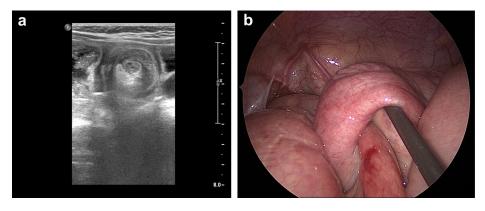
a) Transverse ultrasound image demonstrating small bowel intussusception with classic doughnut or target sign, b) laparoscopic reduction of ileoileal intussusception (involved segment of 12 cm).
